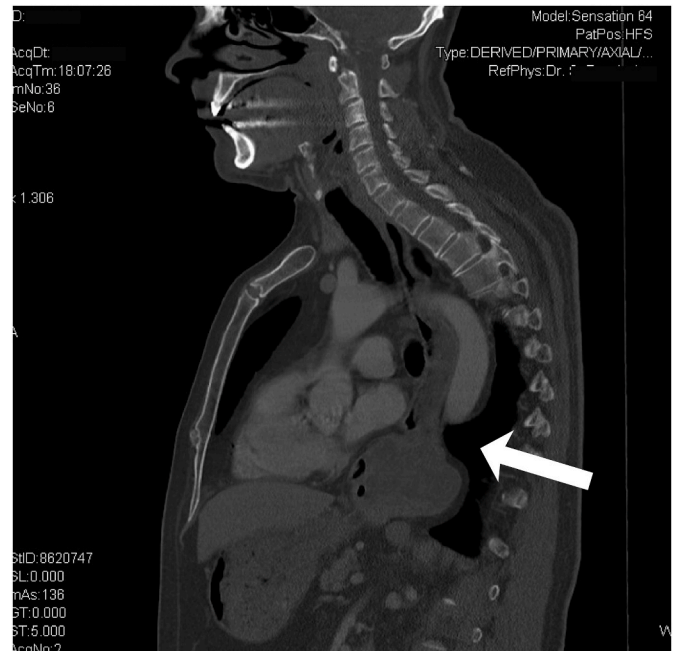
CT showing the paraesophageal hernia, sagittal section.
